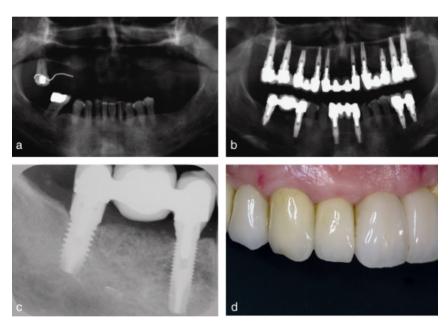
Example of one case involved in the study. (a) Radiograph before surgery; (b) Radiograph after implant placement; (c) Implant osseointegration 5 years post-surgery; (d) Perfect esthetic integration of the definitive prosthesis.
